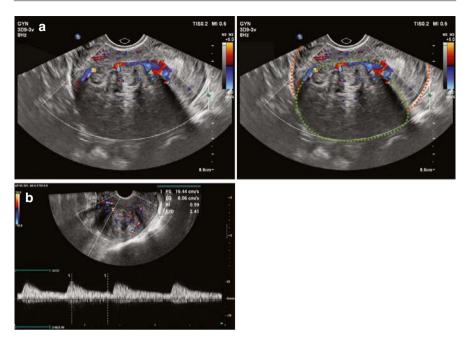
(a) Color Doppler ultrasound reveals semicircular blood flow signals surrounding the fibroid, with branching into the tumor. The uterus is outlined in orange; the fibroid is circled in green. (b) High-resistance arterial flow detected on Doppler ultrasound
